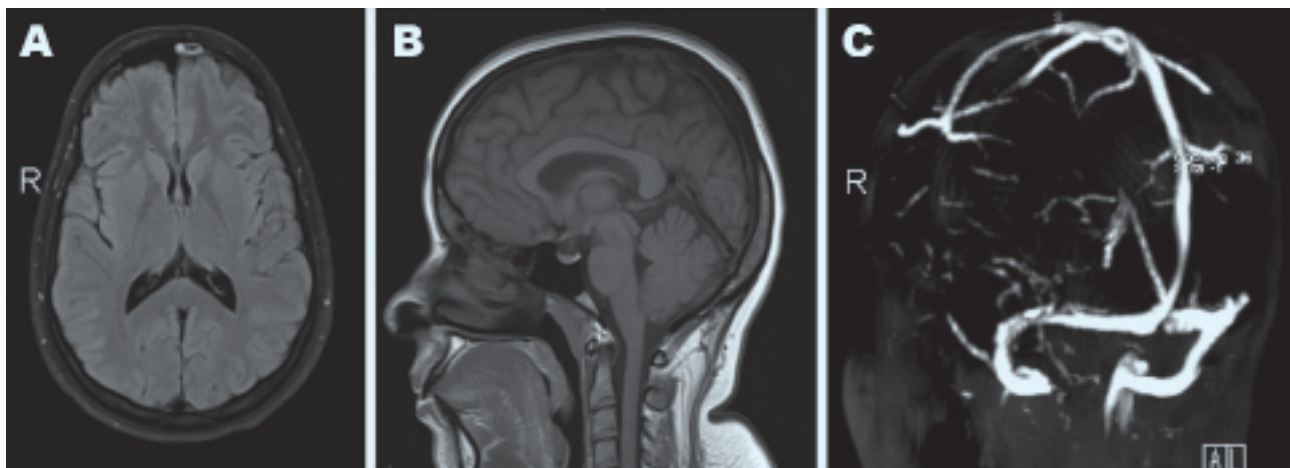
Magnetic resonance imaging of brain (axial fluid attenuated inversion recovery image [A] and sagittal T1 weighted image [B]) showing normal brain parenchyma (no evidence of vasogenic edema of eclamptic encephalopathy or posterior reversible encephalopathy syndrome in the bilateral occipital region, or intra- or extra-axial brain tumor) and cerebral venogram (time of flight image [C]) showing normal major dural venous sinuses. AL - anterolateral, R - right
